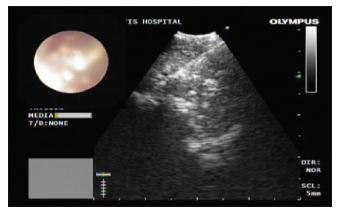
Endobronchial ultrasound image of subcarinal area shows the mass with transbronchial needle aspiration needle in it. The mass appears as homogeneous well-defined round structure, in the upper part of image, with specs of calcification (whitish dots) in it
